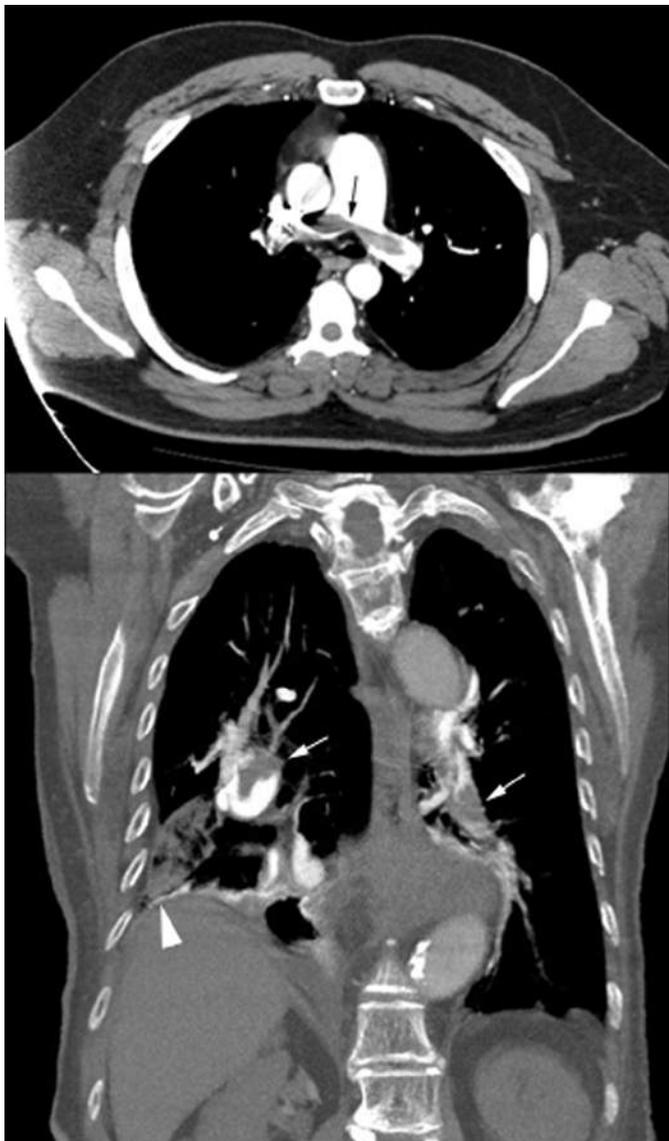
Pulmonary embolism diagnosed by computed tomography angiography. Axial (at the level of the pulmonary artery bifurcation, *upper panel*) and coronal cuts (just anterior to the thoracic spine, *lower panel*) showing the presence of pulmonary embolism involving the right and left pulmonary arteries, also known as *saddle embolism* (arrows). On the coronal cut, there is a wedge-shaped area in the right lower lobe that represents lung infarction (*arrow head*).
